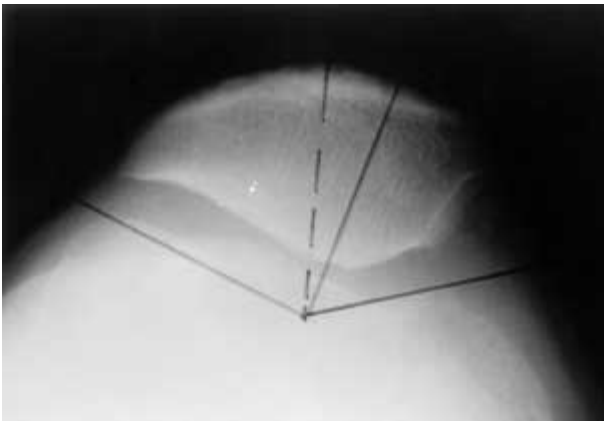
Radiograph showing Merchant's view of a preoperative knee, with normal sulcus and congruence angles.
